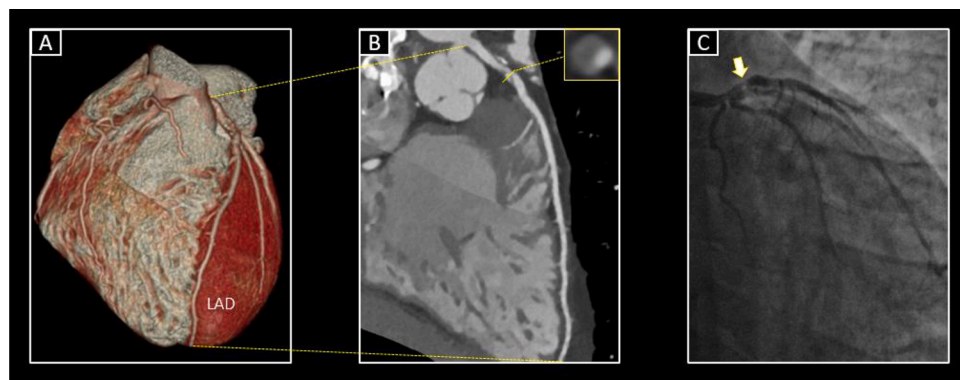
(A) Representative 3D volumetric image of a 44-year-old male patient with significant coronary artery stenosis and a cyclothymic temperament score of 12. (B) Curved multi-planar reformatted image of the left anterior descending artery (LAD) and cross-sectional image of a partially calcified plaque causing severe stenosis. (C) Subsequently performed coronary angiogram. Arrow points to the severe stenosis, corresponding with the location seen on CT. LAD: Left Anterior Descending Artery.
